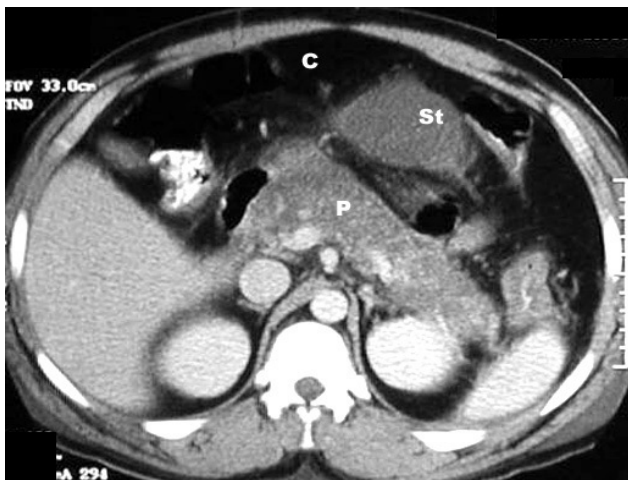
CT scan in acute pancreatitis
